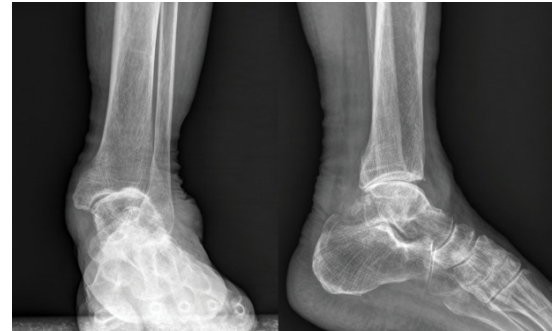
Preoperative radiographs of the ankle showing ankle osteoarthritis with valgus deformity
